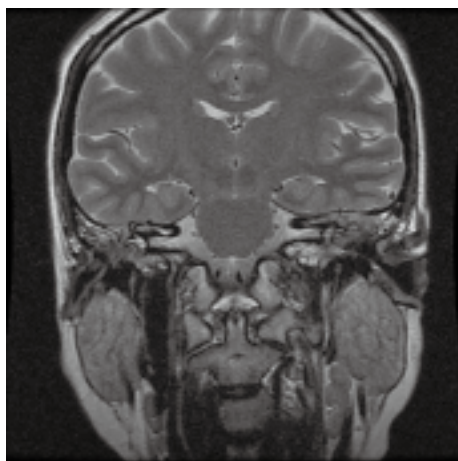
Coronal MRI scan of the temporal bone.
